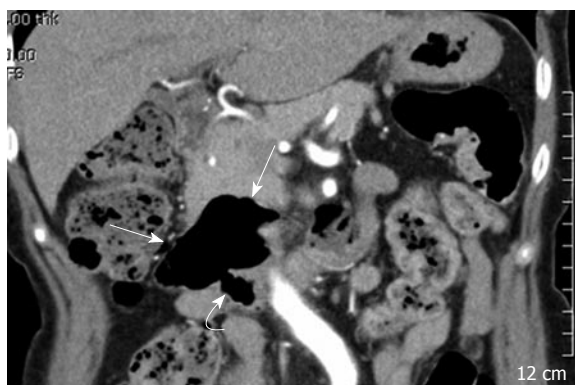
Computed tomography (CT) image two years before the admission shows an approximately 6 cm sized silent diverticulum (arrows) originating from the proximal third portion of the duodenum (curved arrow).
